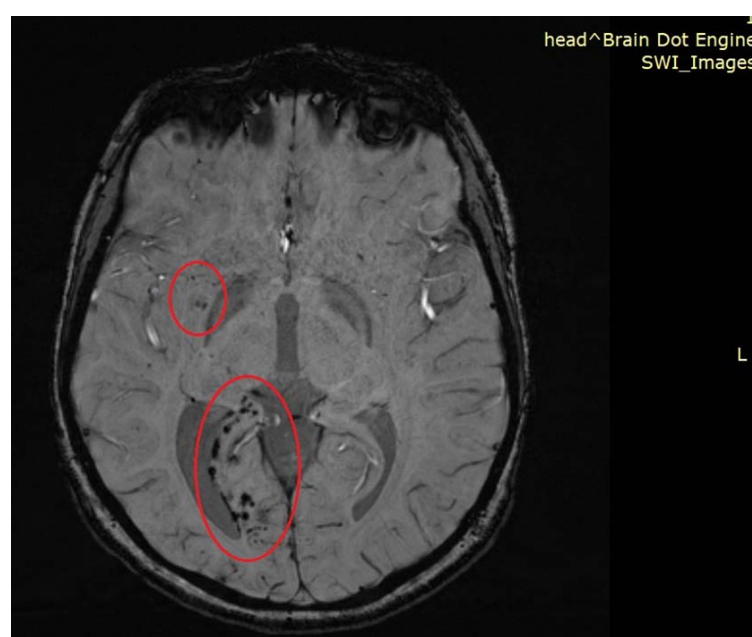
Brain MRI. Foci of haemorrhagic impregnation.
